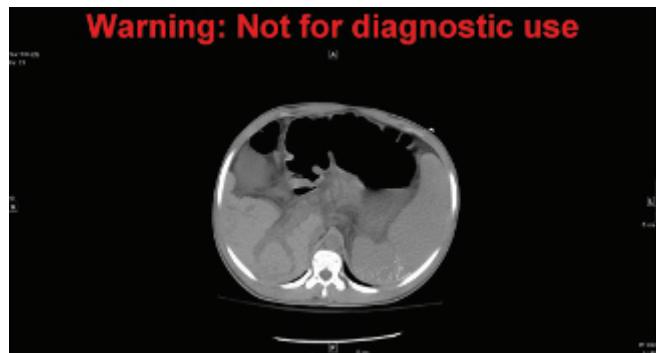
Noncontrast axial computed tomographic scan of the abdomen.
